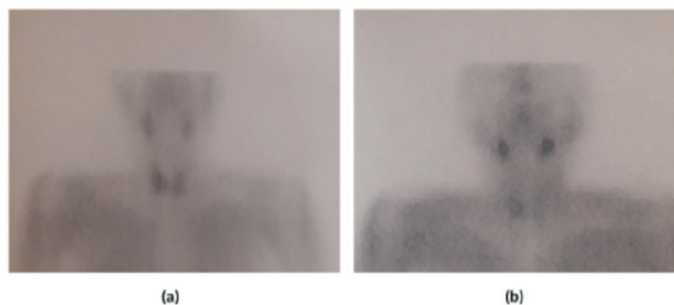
Technetium-99m-MIBI scintigraphy revealed right inferior parathyroid adenoma (a) early image and (b) delayed image
